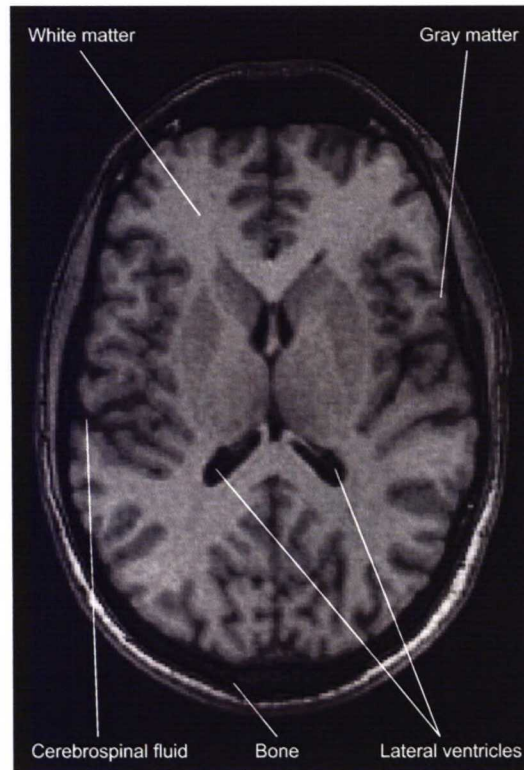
An axial slice of a brain MR image*
